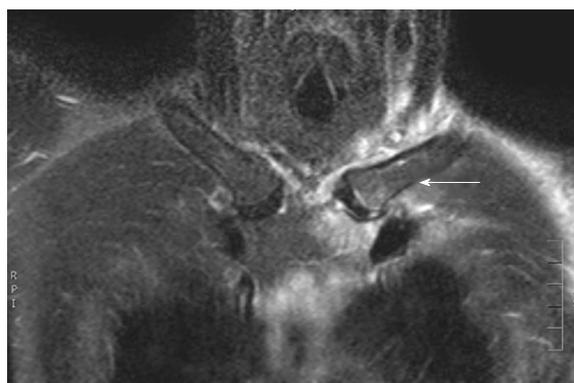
Magnetic resonance imaging of the sternoclavicular area showing edema on the left intraarticular surface of the sternum and the clavicle together with edema of the surrounding soft tissues (arrow).
